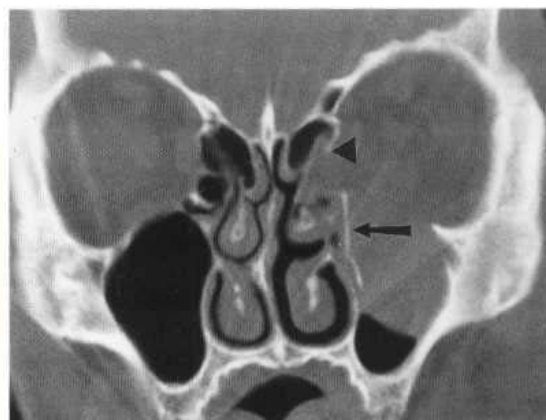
Inferior and medial blow-out fractures. Coronal CT image demonstrates inferomedial displacement of bony fragments of left orbital floor (arrow) as well as accompanying fracture of left lamina papyracea (arrowhead). (Case courtesy of Orlando Ortiz, M.D.)
